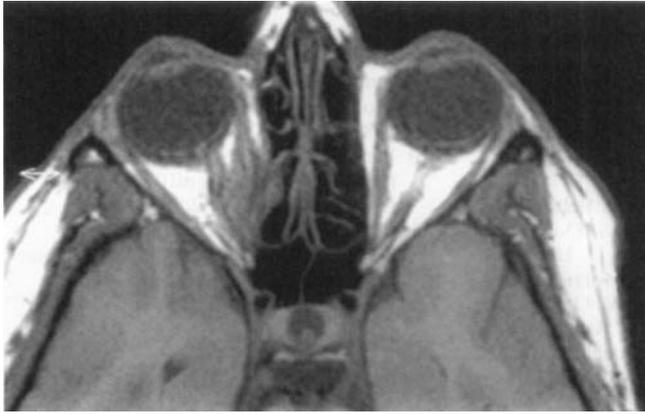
Cranial magnetic resonance. After chemotherapy courses the tumor is still present, reduced in volume, without signs of local invasion (T1-weighted scan)
